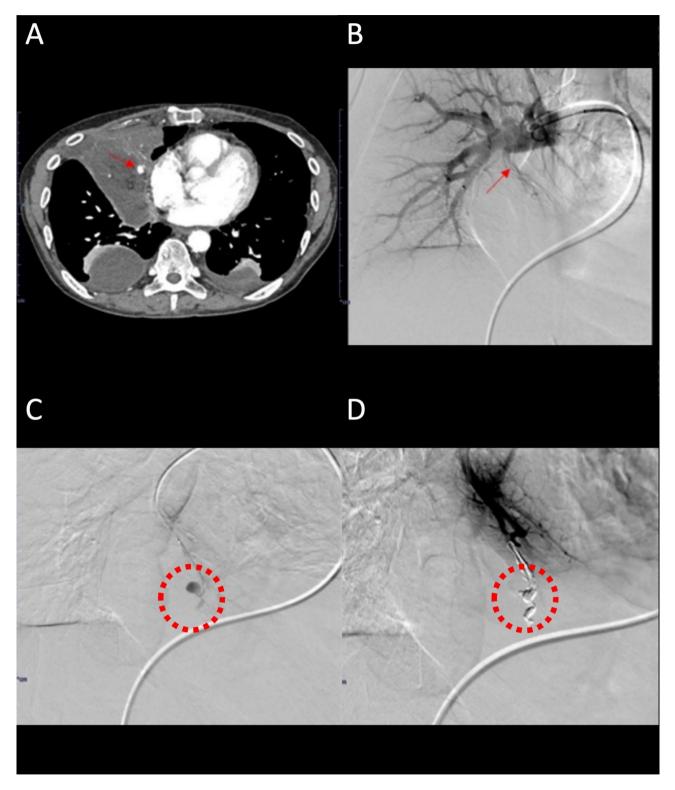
CT scan showing the first pulmonary artery pseudoaneurysm and fluoroscopic images of coil embolization. A Contrast-enhanced CT obtained to detect pseudoaneurysm in A5 branch (red arrow). B Angiography to identify the responsible vessel (red arrow). C Aneurysm delineated by red dashed circle. D Coil embolization of the pseudoaneurysm (red dashed circle)
